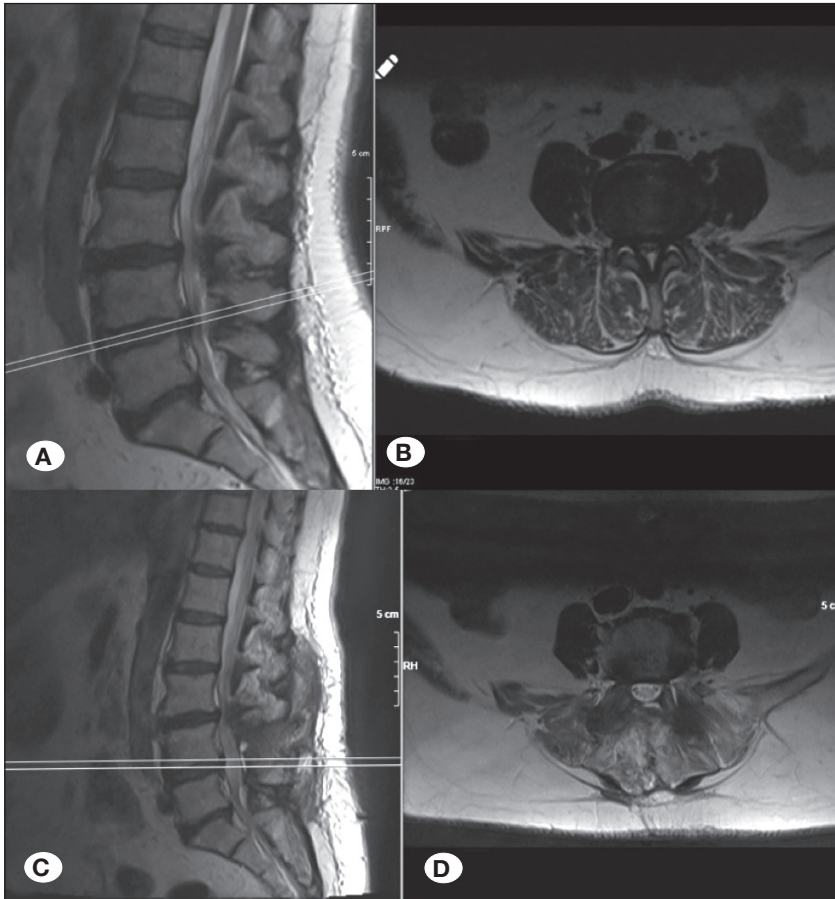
Preoperative (A,B) and postoperative (C,D) sagittal and axial T2W-MR images of a case with L4-5 lumbar spinal stenosis who underwent L4 total laminectomy with L4-L5 pedicle screw instrumentation.
